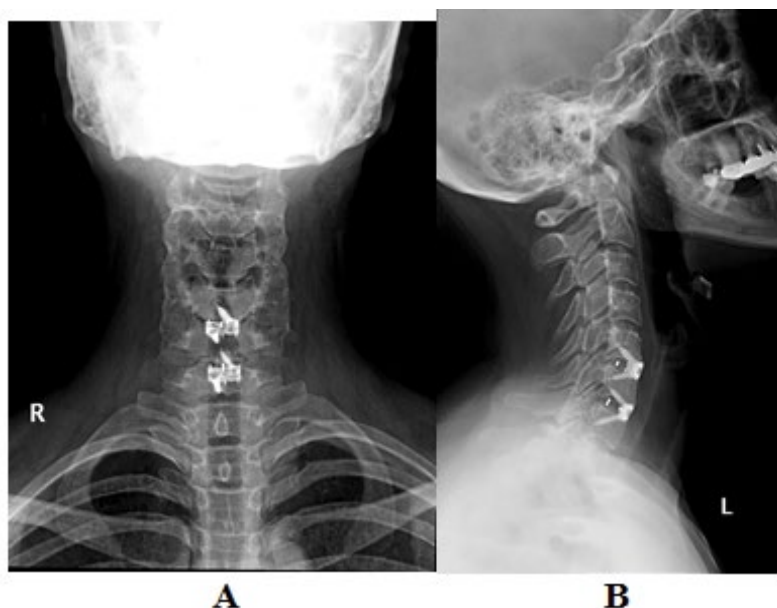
Radiographs taken at one year follow up in AP and Lateral view in figures A and B respectively
